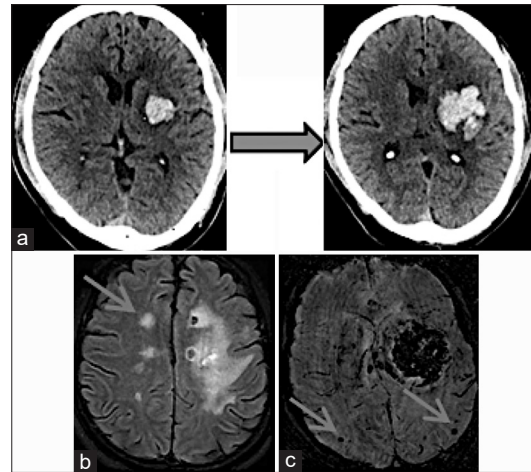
Depicts (a) hematoma expansion in initial and follow-up CT, (b) white matter hyperintense lesions in T2 FLAIR sequences in the contralateral hemisphere, (c) microbleeds in susceptibility WI MR sequence
